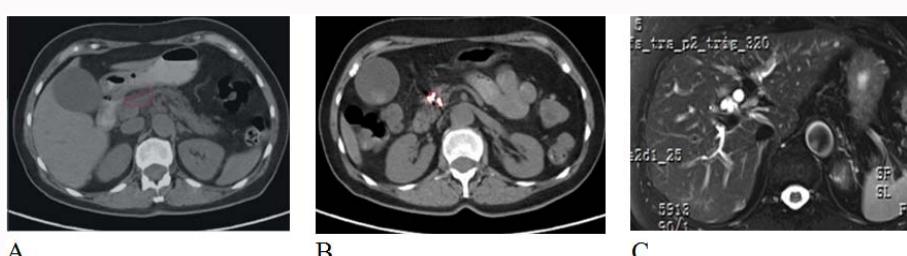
A: Example 7 CT showing a space-occupying lesion in the neck of the pancreas with liver metastasis (liver metastasis not shown); B: After TTV treatment, the pancreatic tumor shrank and the liver metastasis disappeared; C: MR showed recurrence of liver metastases 7 years later.
